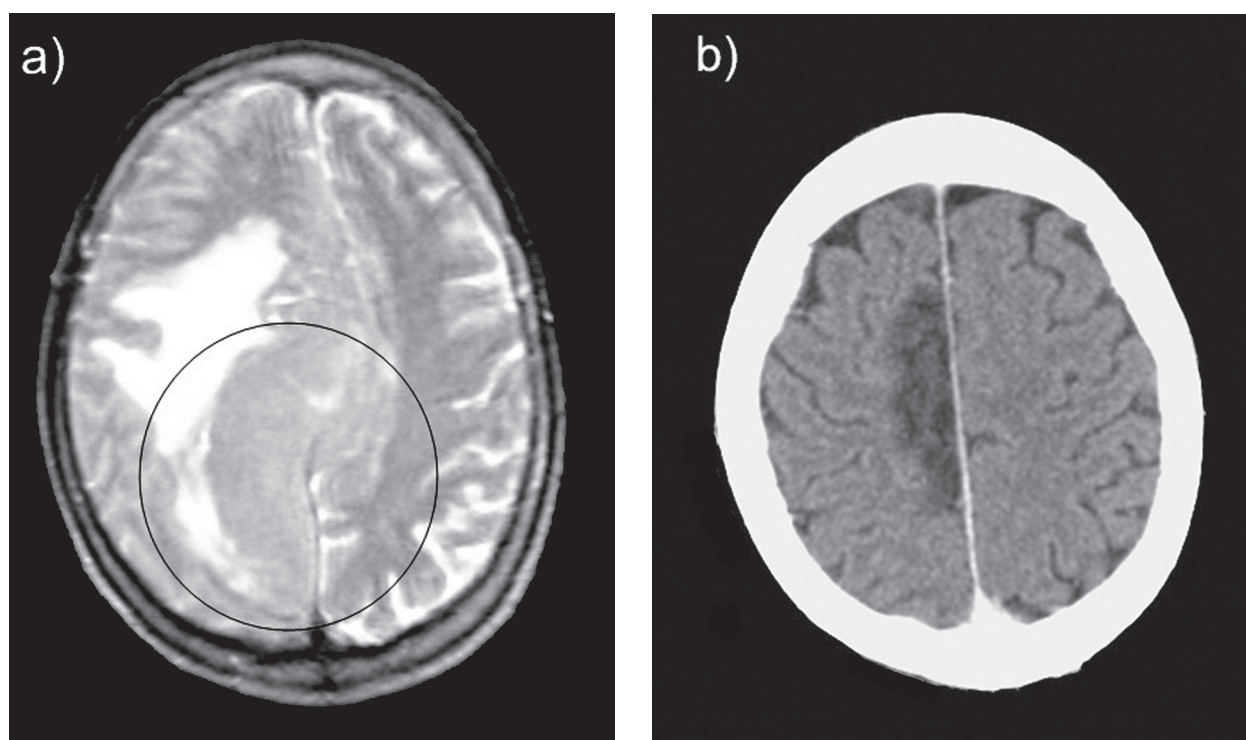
(a) MRI T2 weighted preoperative image: large parieto-occipital tumor; radiological interpretation: meningioma; (b) CT scan 1 month after radiation: parieto-occipital defect, no midline shift.
